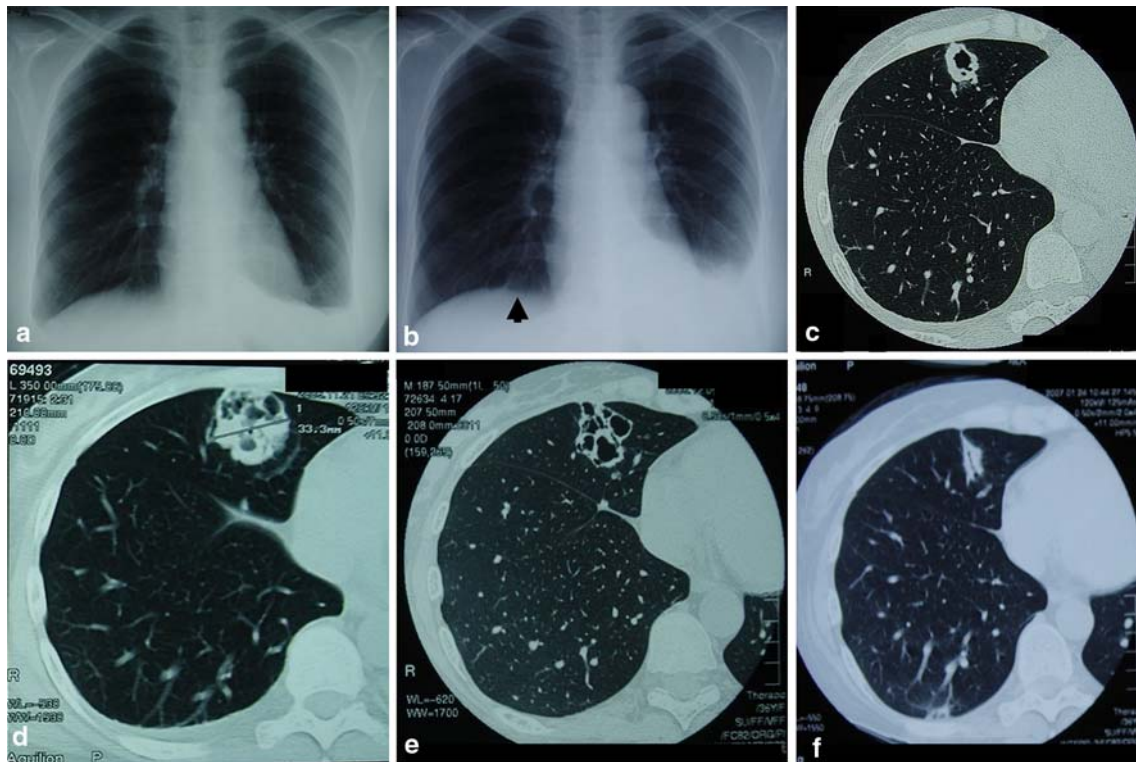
Plain chest X-ray film obtained on admission (a). No abnormal shadows are present in the lung fields, excluding bilateral pooling of pleural effusion. Plain X-ray film obtained on day 20 after admission (b). A small mass lesion is evident in the right lower lung field. Chest CT films obtained on days 34 (c) and 62 (d) after
